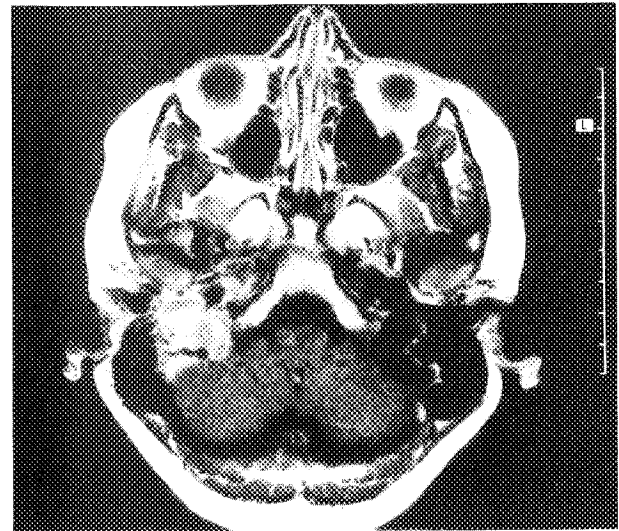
T1-weighted, post gadolinium MRI scan (case 2) of cystic fibrous dysplasia of right hypotympanum and jugular fossa region with extension to posterior fossa.
